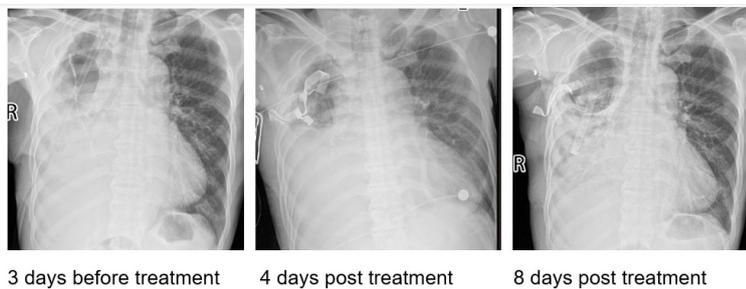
Patient clinical data during phage therapy. (C). The patient's chest X-rays 3 days before phage therapy and on day 4, 8, 19, 25, and 33 after phage therapy.
